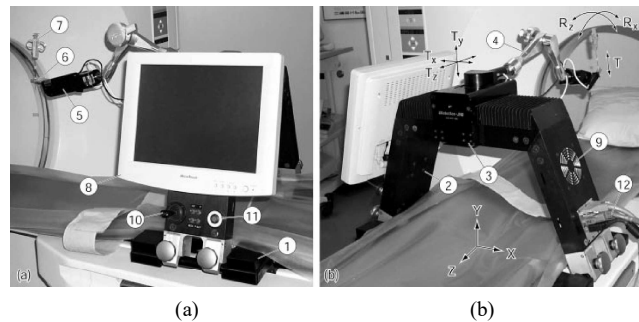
(a) Front and (b) side views of the AcuBot mounted on a CT scanner.
